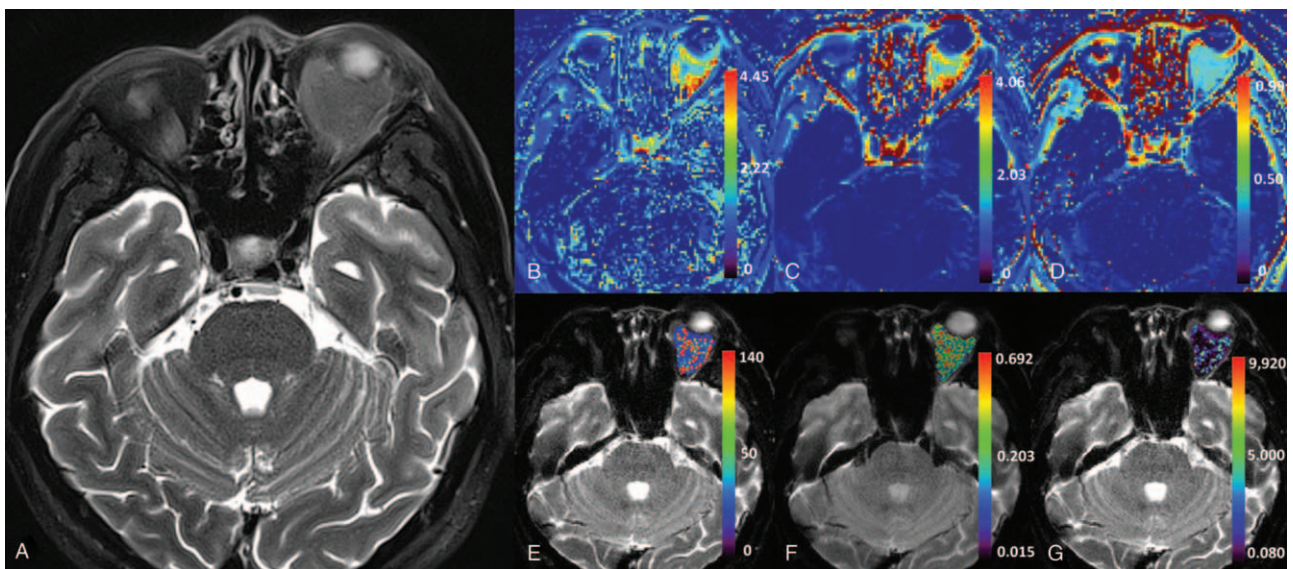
A 54-year-old woman with orbital cavernous malformation. The lesion shows as high signal intensity on T2-weighted image (compared with cerebral cortex) (a). The values for  $K_{ep}$  (b),  $K^{trans}$  (c), and  $V_e$  (d) are  $0.956 \text{ min}^{-1}$ ,  $0.725 \text{ min}^{-1}$  and  $0.771$  (upper row), and the values for  $D$  (e),  $D^*$  (f), and  $f$  (g) are  $1.284 \times 10^{-3} \text{ mm}^2/\text{s}$ ,  $42.371 \times 10^{-3} \text{ mm}^2/\text{s}$  and  $0.118$  (below row), respectively.
